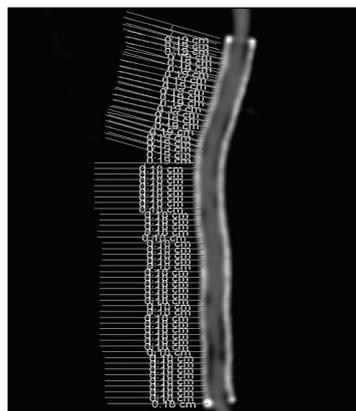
CTA (coronal reformation) of an implanted stent at 1-year follow-up. The bright white lines represent the stent surface, and the grey area inside the stent is the perfused lumen. Adjacent to the inner stent wall, there are black neointima formations that narrow the perfused lumen to a various extent.
